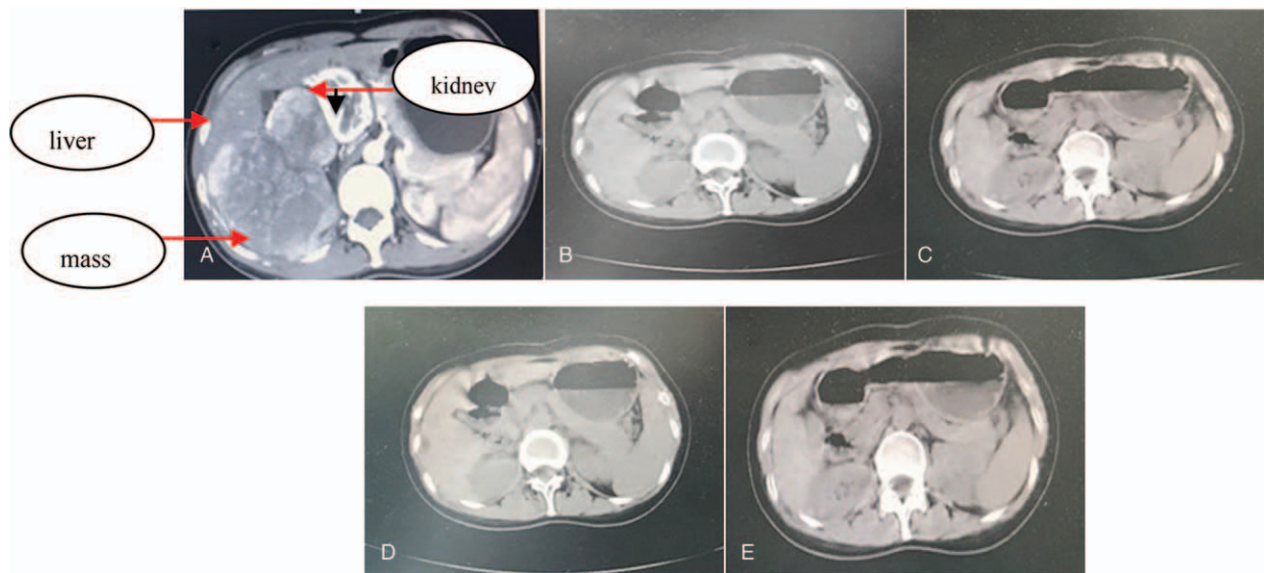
Abdominal enhanced CT scan revealed a retroperitoneal cystic solid mass ($16 \times 10 \times 10$ cm) located in the right upper abdomen, and the liver and right kidney were locally extruded. (A) Postoperative changes of retroperitoneal plasmacytoma without recurrence or metastasis after the operation; (B) postoperative and postradiotherapy changes of retroperitoneal plasmacytoma without recurrence or metastasis 4, 8, and 12 months after the radiotherapy, respectively (C, D, and E). CT=computed tomography.
